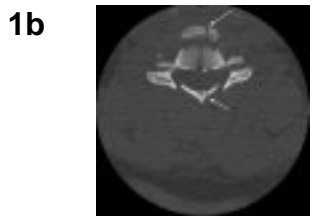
and 1c (Computed Tomography): Axial and sagittal CT of the same patient demonstrating the burst fracture of the C5 vertebral body (arrow).
